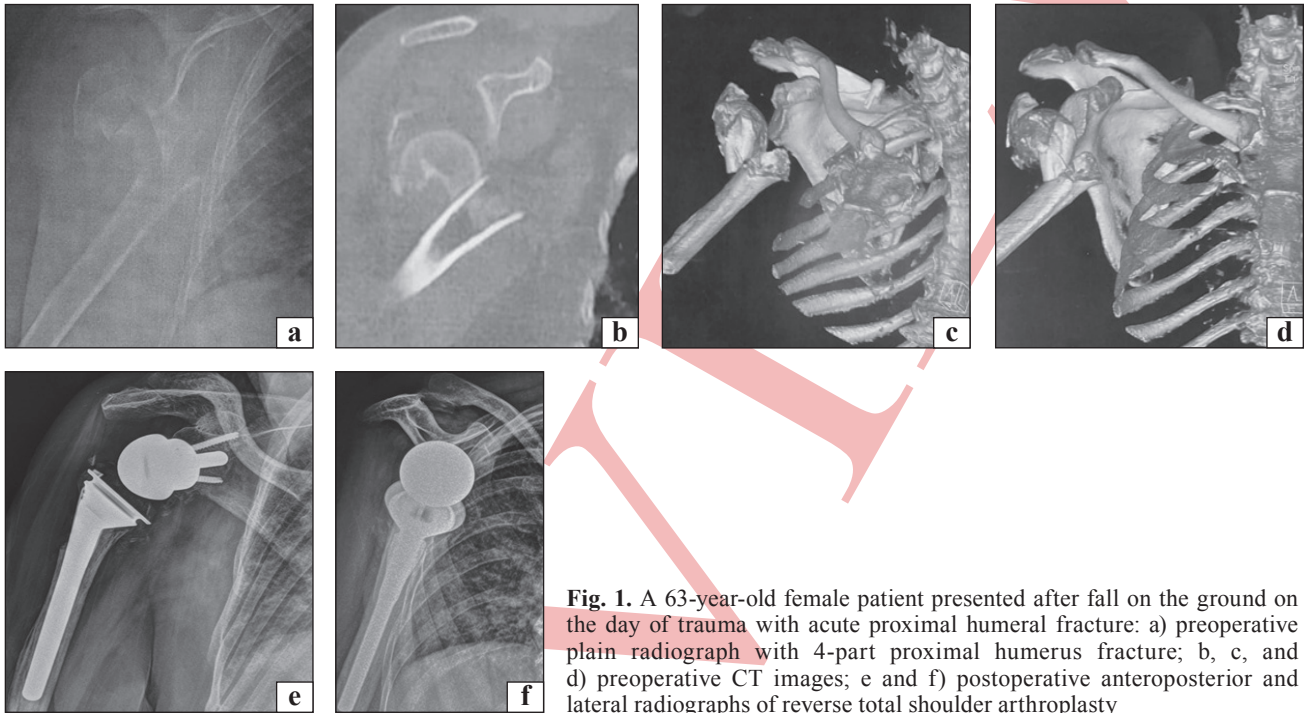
A 63-year-old female patient presented after fall on the ground on the day of trauma with acute proximal humerus fracture: a) preoperative plain radiograph with 4-part proximal humerus fracture; b, c, and d) preoperative CT images; e and f) postoperative anteroposterior and lateral radiographs of reverse total shoulder arthroplasty
